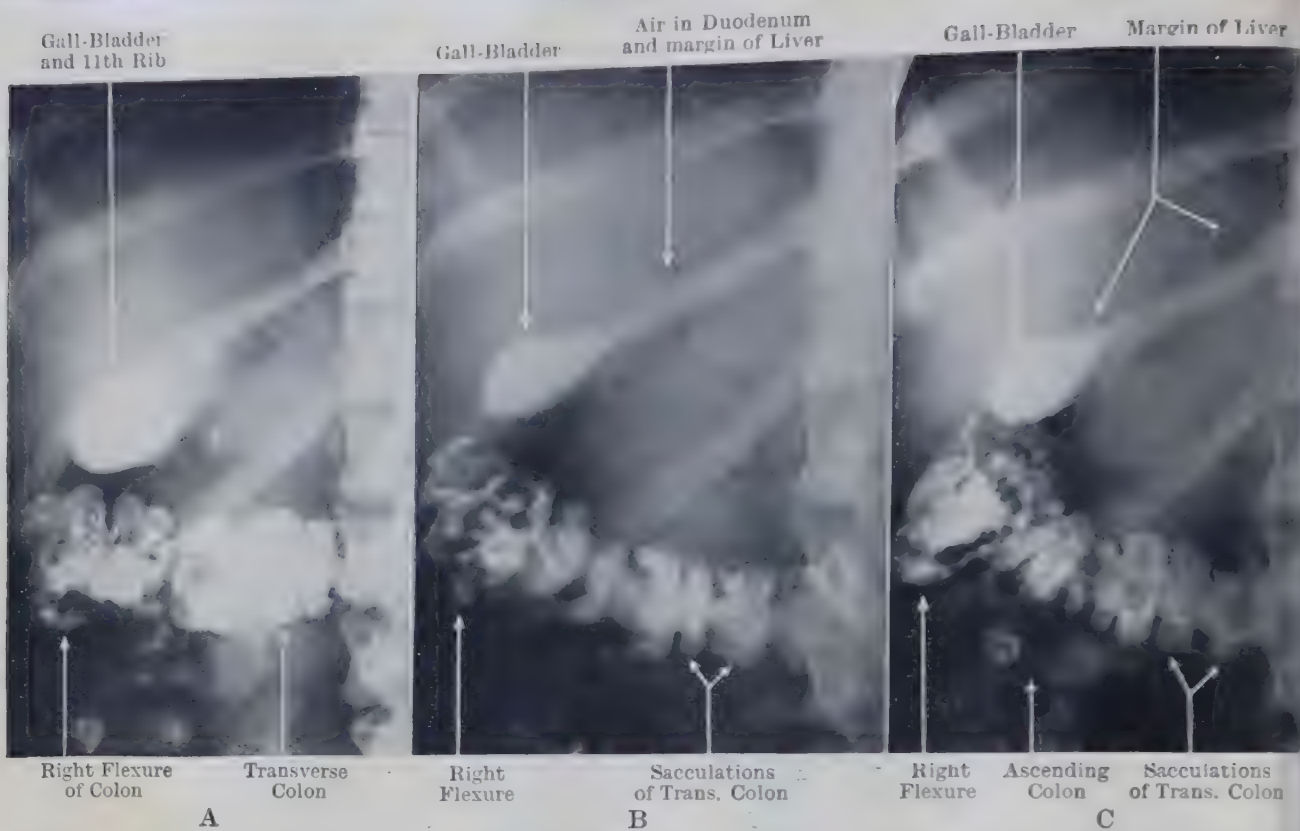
SERIAL RADIOGRAPHS OF GALL-BLADDER (WOMAN, AGED 44) SHOWING PHYSIOLOGICAL CHANGES AFTER ADMINISTRATION OF SODIUM-TETRA-iodo-PHENOL-PHTHALEIN. (See pp. 667 and 1556.)
